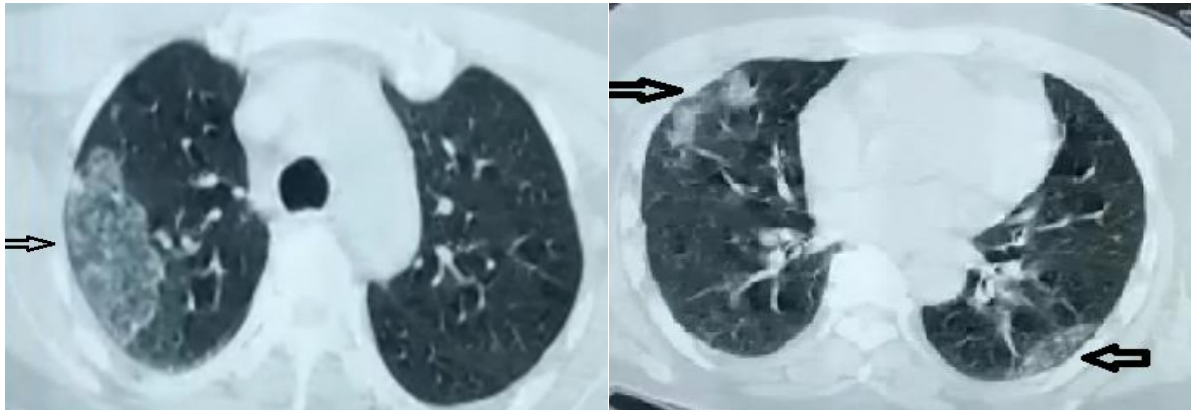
Transverse chest HRCT scans series from a 70-years-old man with common COVID-19 pneumonia (a) after symptom onset: multifocal round or patchy ground-glass opacity in bilateral lobes. Multifocal irregular consolidation
